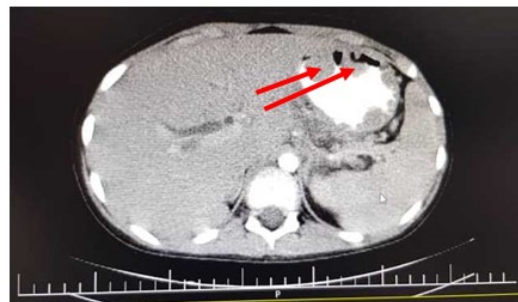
Abdominopelvic CT scan (multiple polyps in stomach)
